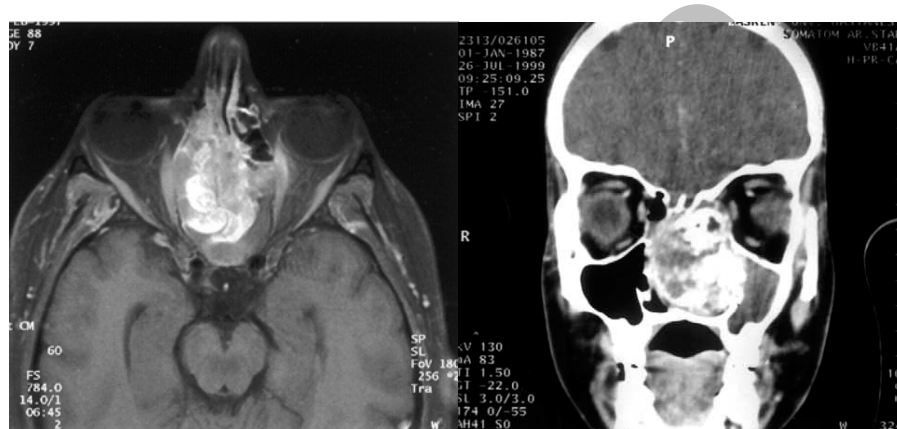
Axial MRI and coronal CT scans of patient No2
